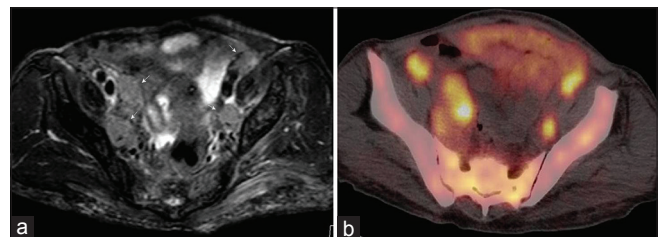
(a) Axial fat-saturated T2-weighted MR image shows multiple enlarged, homogeneously hyperintense internal and external iliac lymph nodes (arrows). (b) Axial ⁶⁸Ga-PSMA PET/CT shows significant tracer accumulation in the enlarged pelvic lymph nodes
